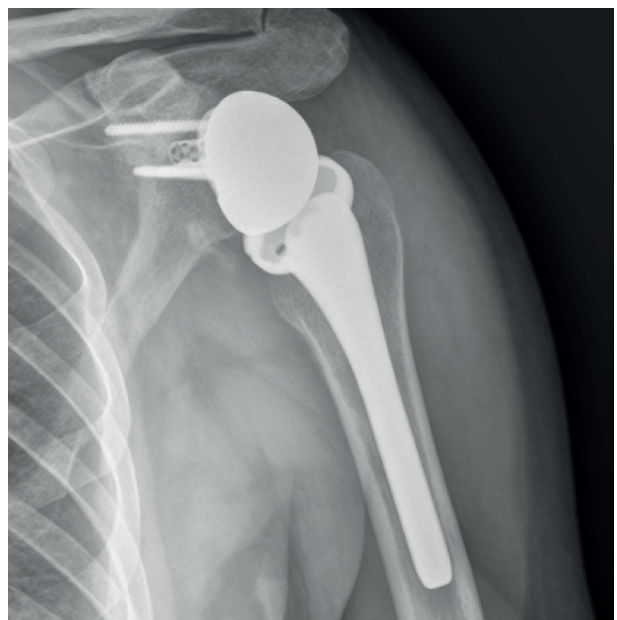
Post-operative x-rays examination
